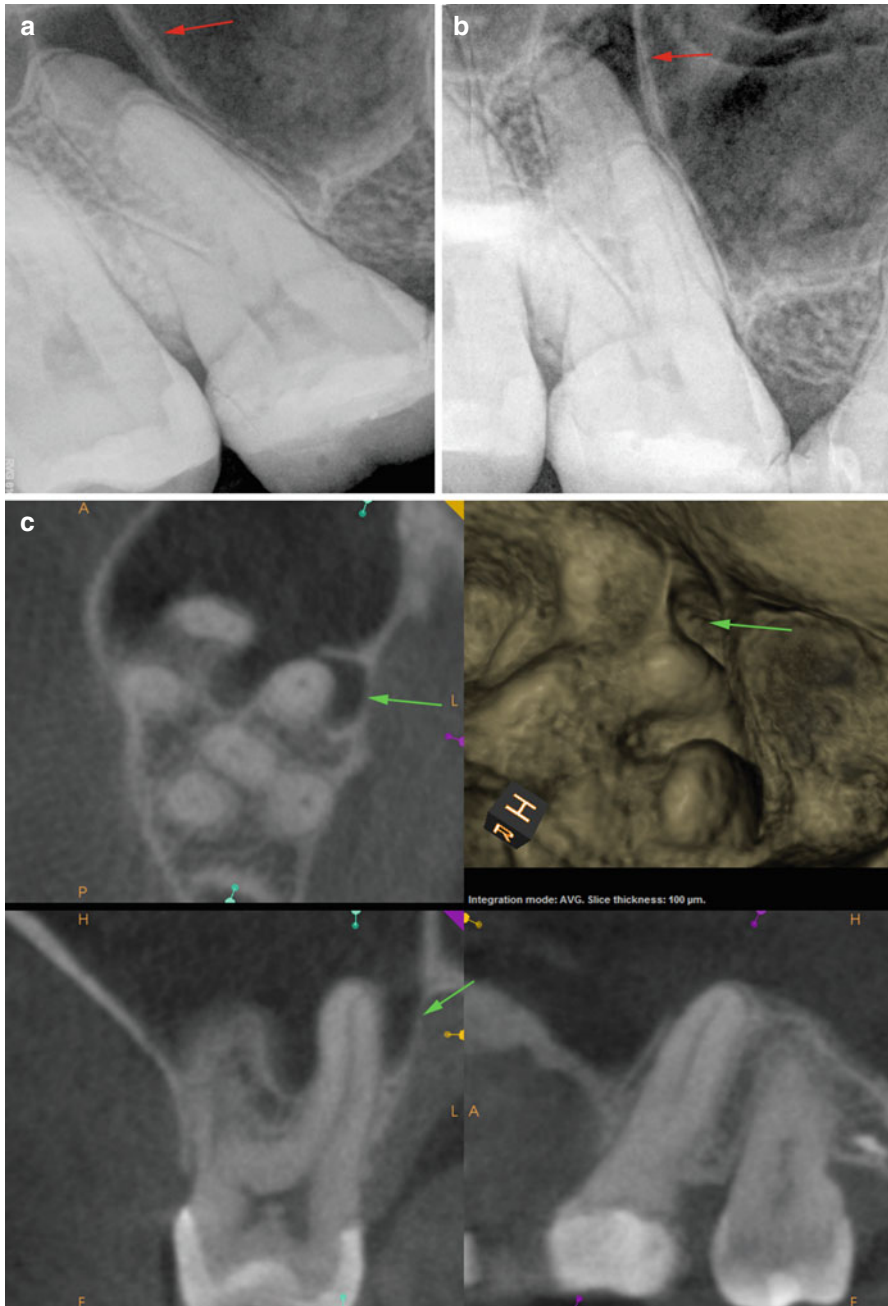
(a, b) Periradicular radiographs of a maxillary first molar tooth showing what appears to be a radiolucency associated with the palatal root; (*red arrows*). (c) CBCT of the same tooth clearly showing that region of radiolucency is related to the position of the maxillary sinus relative to the apex of the palatal root; (*green arrows*)
